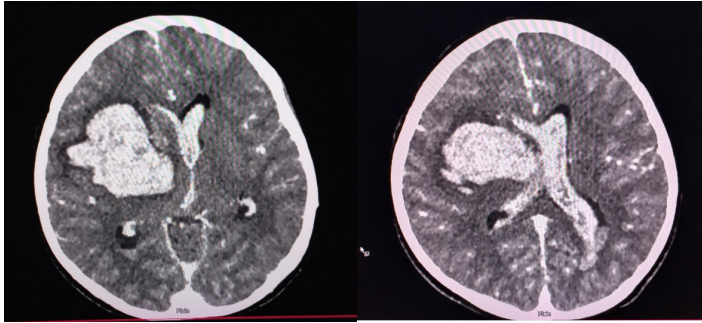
CT angiogram showing AVM in the right caudate head having a feeder artery (lenticulostriate branch of the right middle cerebral artery) and draining vein (medullary vein)
